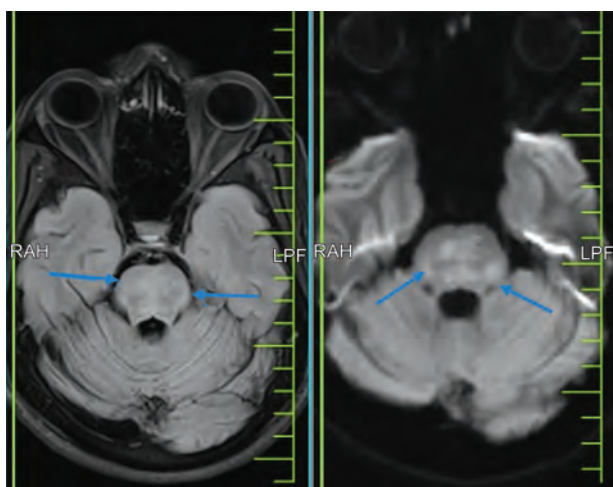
Showing hyperintensities in the pons on FLAIR and DWI images
